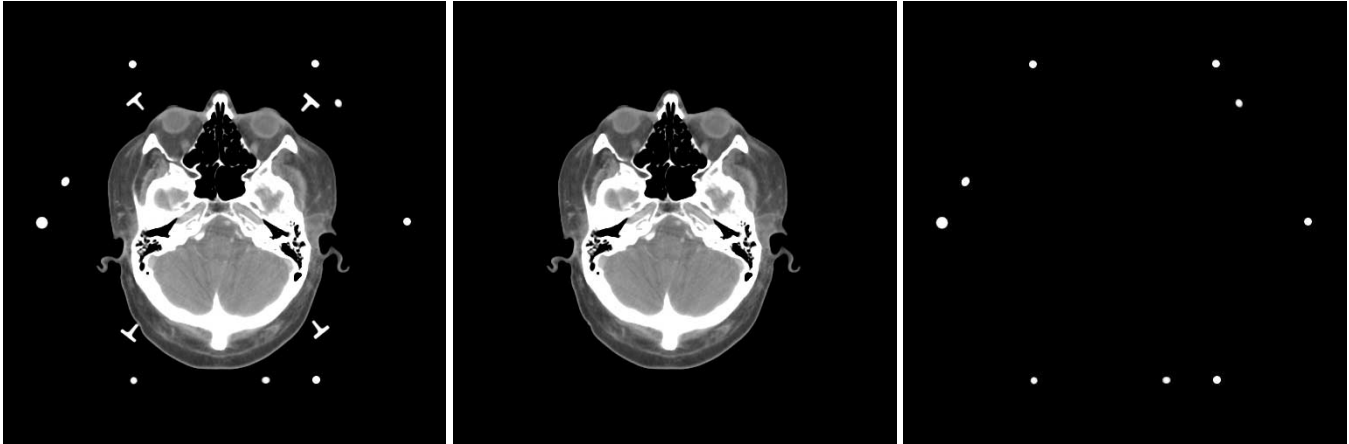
Separation of original CT image (*left*) into head-only (*center*) and frame-only (*right*) images. The three N-bars appear as nine circles (the diagonal rods are ellipses) in a transverse (cross-sectional) image slice such as the one on the left. The four posts used to attach the reference frame (head ring) to the head have a T-shaped cross section in a transverse image. These posts are removed from both the head-only and frame-only images. Thus the frame-only image contains only the three N-bars.
